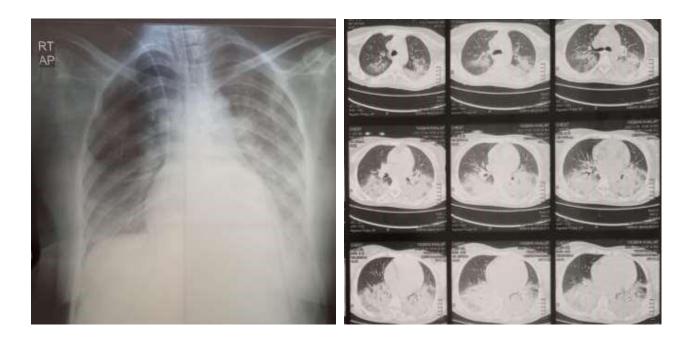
X-ray chest of female patient 22 years old with bilateral lower bilateral lower lobe consolidation
